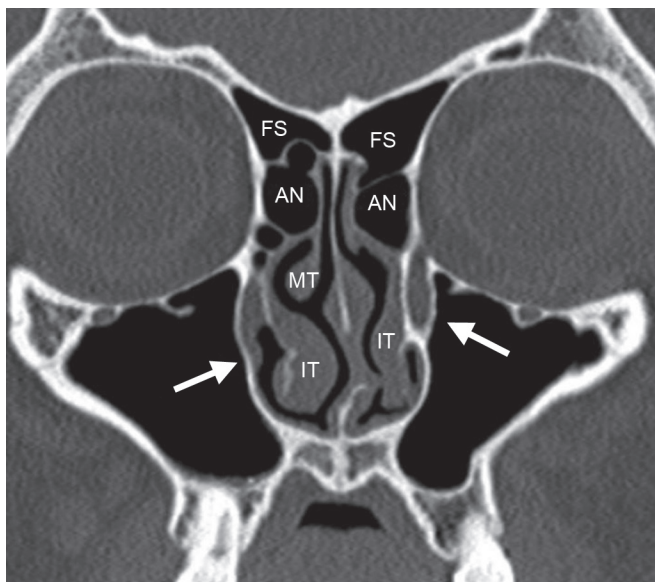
Anterior coronal CT through the frontal sinuses (FS) demonstrates paired Agger nasi (AN) cells. Agger nasi cells are very common (90% prevalence), and represent the most anterior variable ethmoidal air cells. They are located within the lacrimal bone, and above the attachment of the middle turbinate (MT). Note arrows denoting nasolacrimal ducts draining into the inferior meati, lateral to the inferior turbinates (IT).
